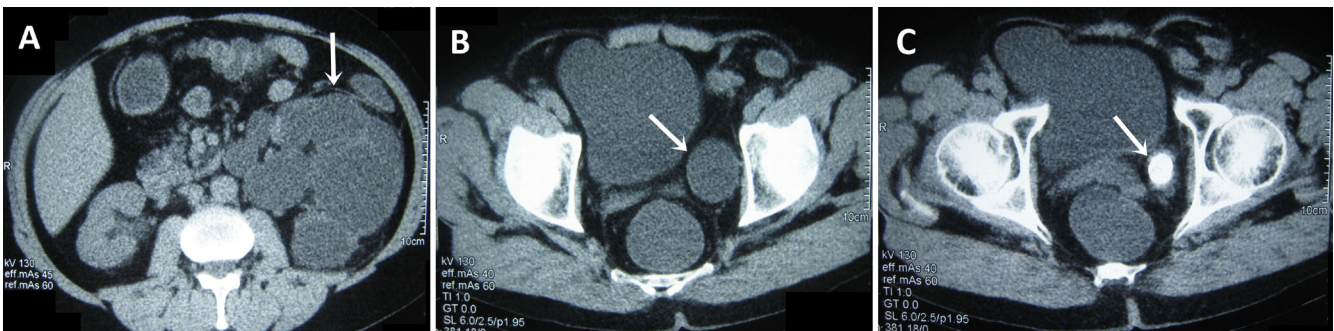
Computed tomography scan of the abdomen revealing giant hydronephrosis (arrow) (A), massive hydroureter (arrow) (B) and distal giant left ureteral stone (arrow) (C).
